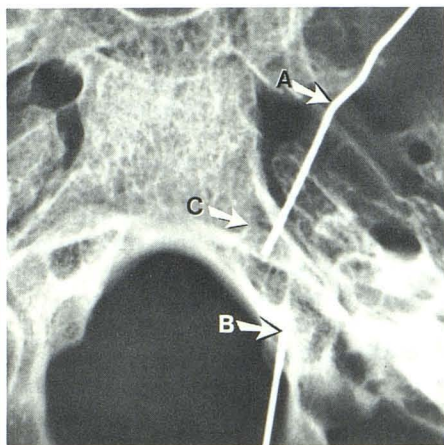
Dried skull radiograph. A = tip in anterior condylar fossa appears inside pseudofoamena; B = tip adjacent to medial border of hypoglossal canal; C = bony ridge for insertion of longus capitis muscle.
